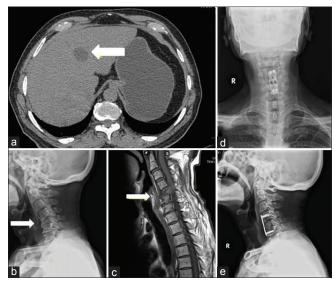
(a) Computed tomography image showing hepatocellular carcinoma. (b) Radiography showing collapse of the C5 secondary to metastasis from hepatocellular carcinoma. (c) Sagittal T1 magnetic resonance image showing collapse of the C5 vertebra and compression of spinal cord. (d and e) Radiographs showing anterior decompression of the spinal cord and stabilization of C5 with plate
